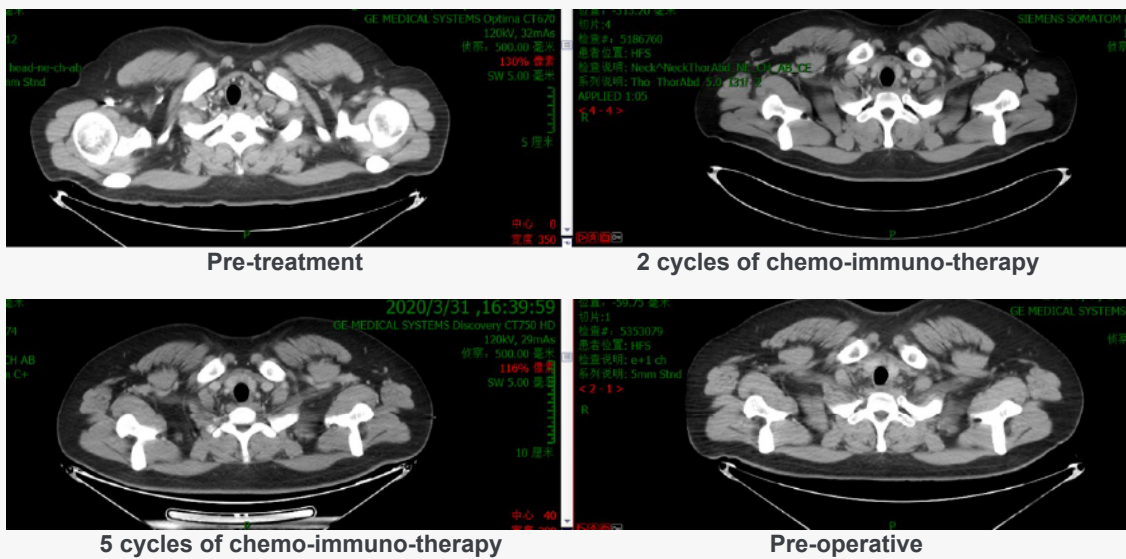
Reassessment of cervical esophageal lesions by CT
